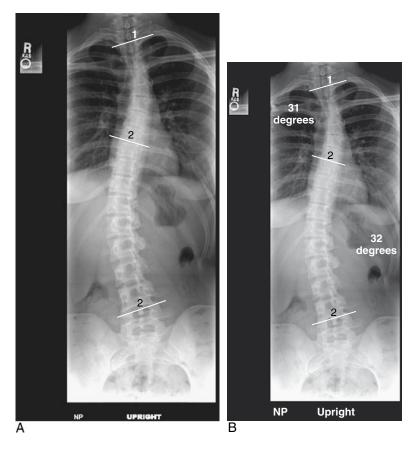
A. Posteroanterior radiograph of the spine showing adolescent idiopathic scoliosis. B. Radiographic determination of the Cobb angle in the same patient.
